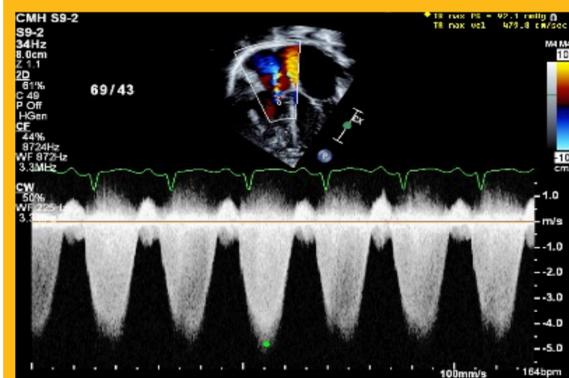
CW doppler of tricuspid regurgitation jet estimating supra-systemic PHN on presentation.
